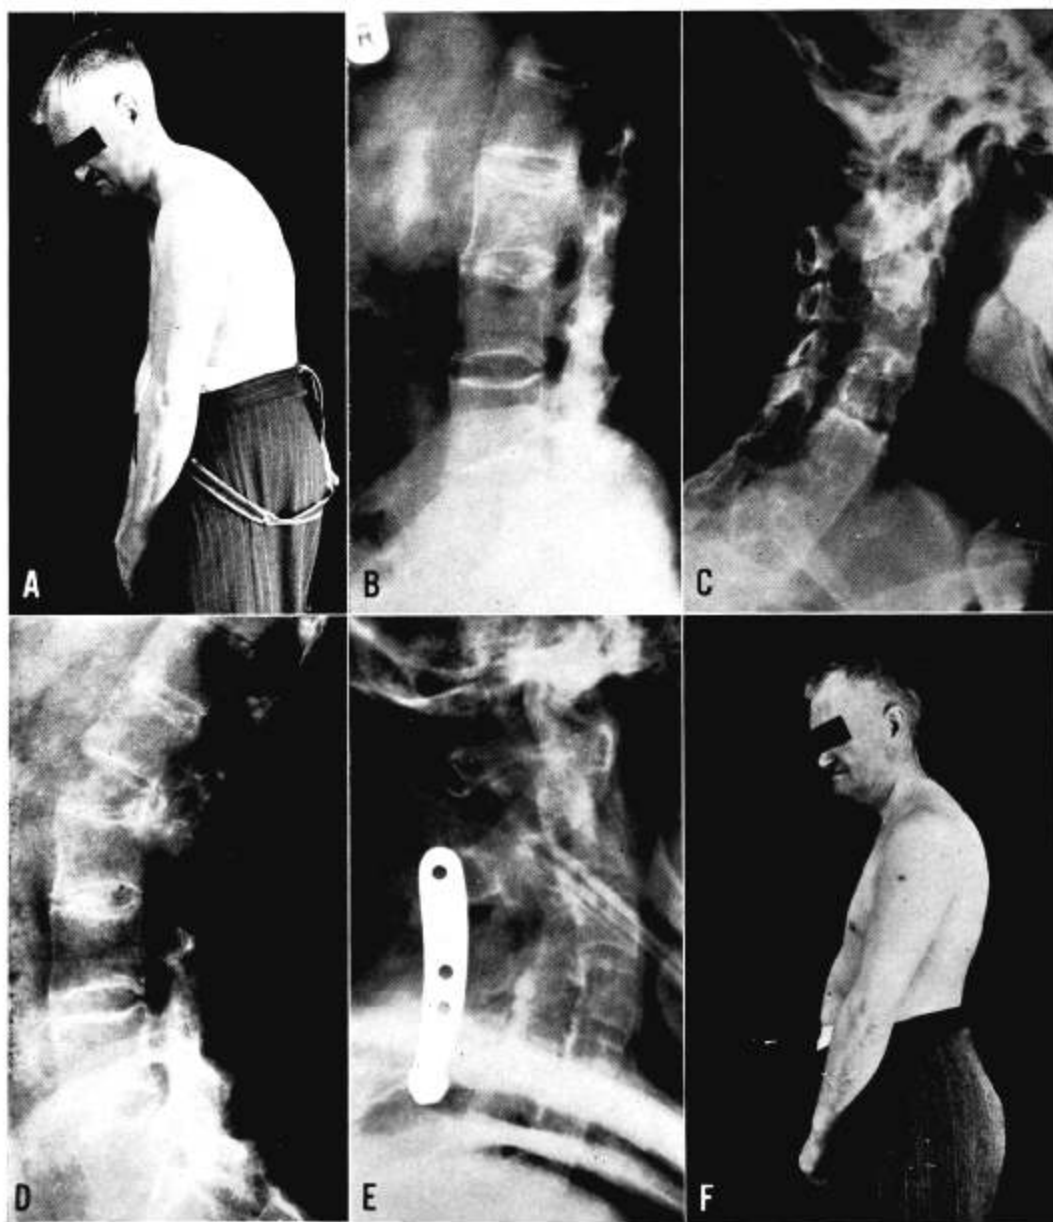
A-F. Combined lumbar and cervical spinal osteotomy. A, Preoperative photograph of patient. B, Radiograph of lumbar spine. C, Preoperative radiograph of cervical spine. D, Correction after lumbar spinal osteotomy. E, Correction after cervical spinal osteotomy. F, Postoperative photograph of patient.
